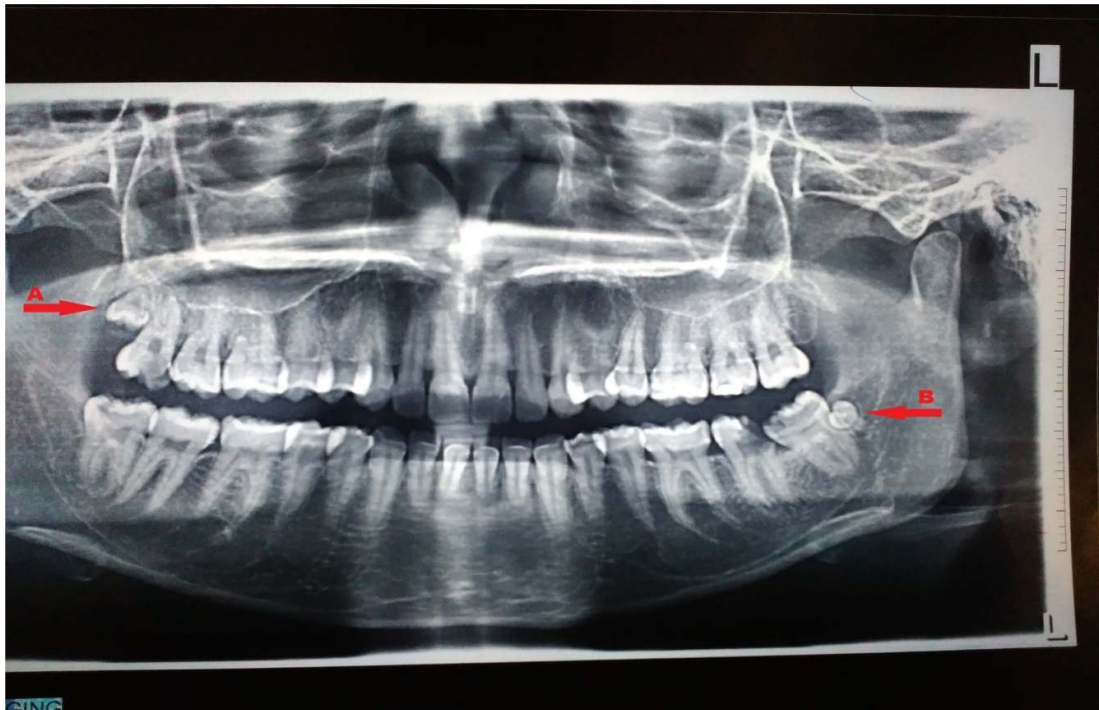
Panoramic radiograph showing impacted right maxillary (arrow A) and left mandibular disto-molars (arrow B)
